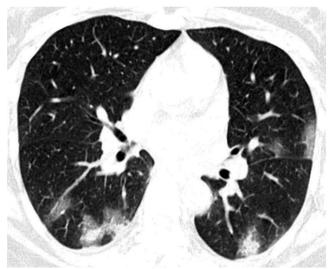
Axial HRCT image showing vascular dilatation and bronchiolar dilatation
